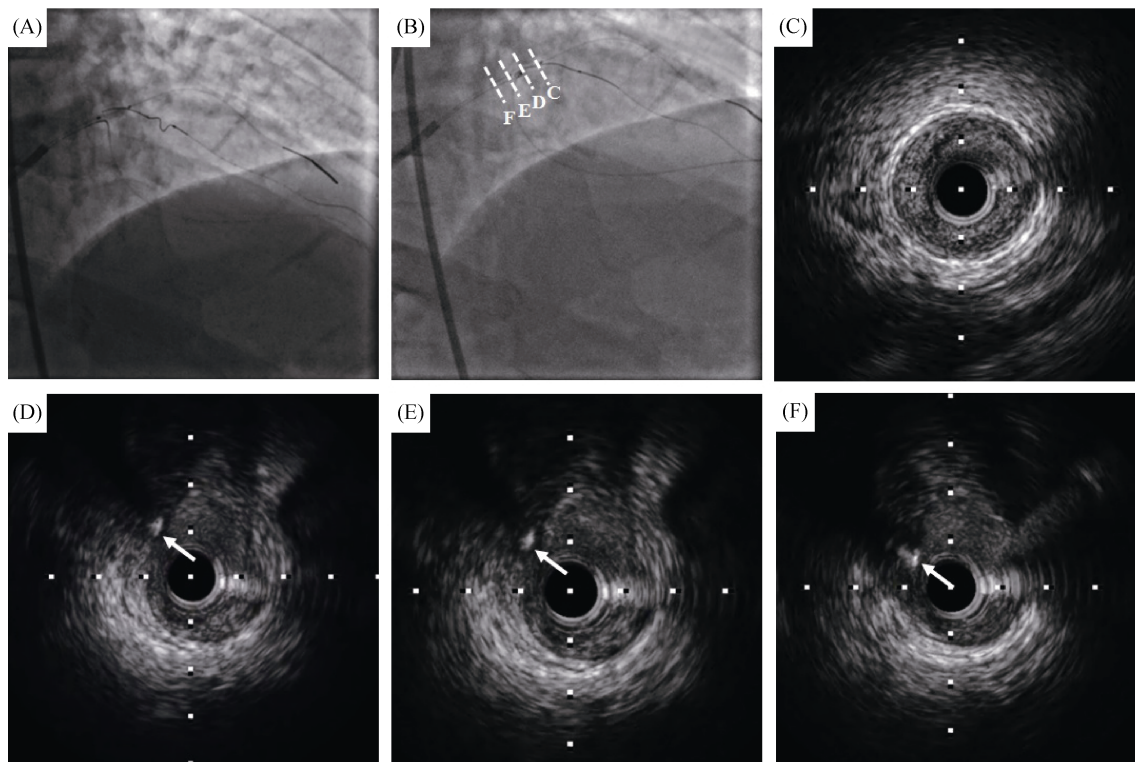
Cutting balloon inflation released the guidewire from the intimal layer. (A): 2.75 mm × 10 mm cutting balloon was inflated at the bifurcation site; (B): IVUS probe was pulledback from the first diagonal branch; and (C & D & E & F): IVUS imaging demonstrated that the retrograde guidewire was released from the intimal layer and entered into the proximal true lumen. Arrow indicated the retrograde guidewire. IVUS: intravascular ultrasound.
